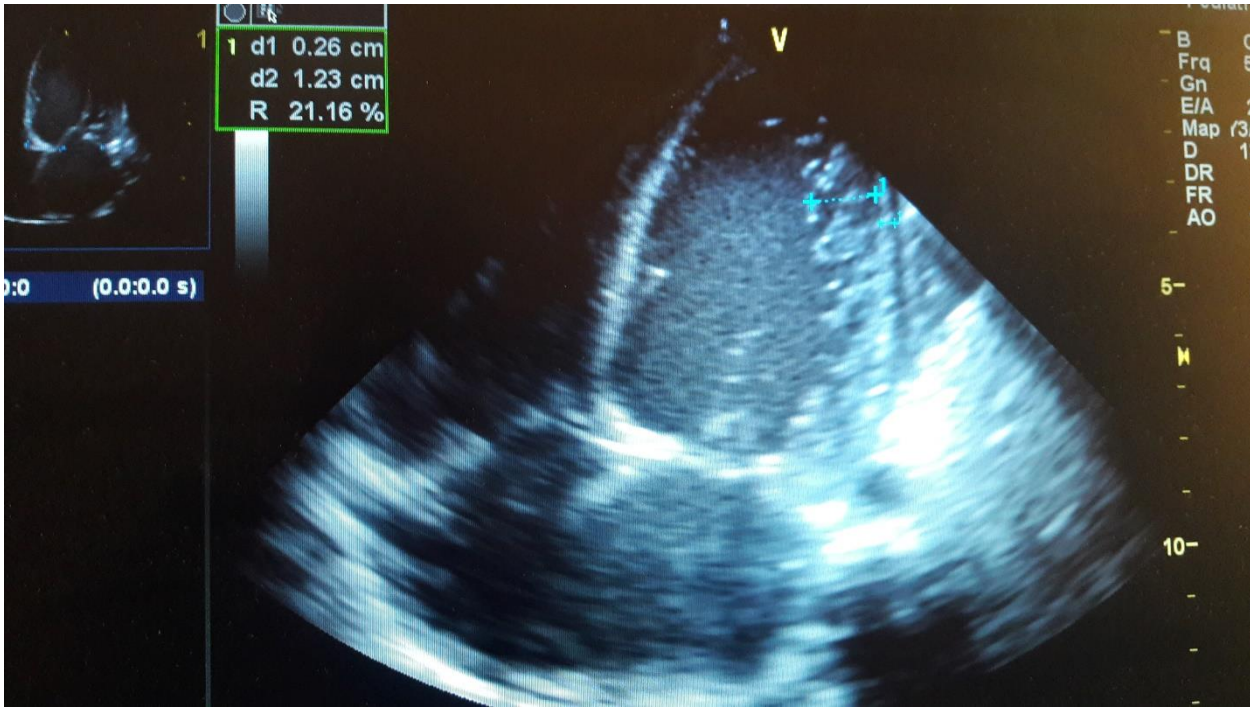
Apical 4-chamber transthoracic echocardiographic image of patient with LVNC demonstrating prominent ventricular trabeculations and deep intertrabecular recesses predominately in the apical and lateral walls. Original clinical image from UATH non-invasive cardiac laboratory.
